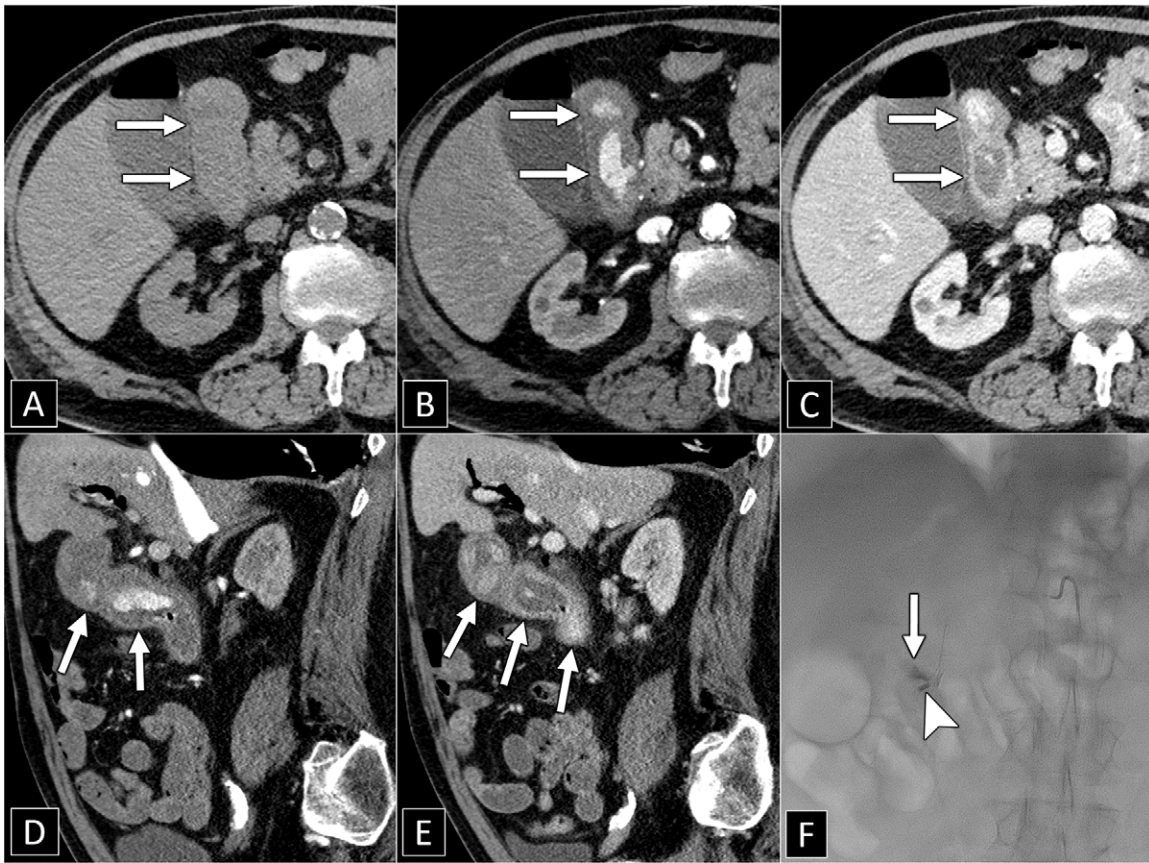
Actively bleeding duodenal ulcer in a 70-year-old man with a history of a large duodenal ulcer previously treated with endoscopic clipping who presented with recurrent gastrointestinal (GI) bleeding. (A) Noncontrast, (B) arterial phase axial and (D) sagittal, and (C) portal venous phase axial and (E) sagittal CT images show high-attenuation fluid in the duodenum on noncontrast images (arrows in A), representing a sentinel clot. On contrast-enhanced images, there is arterial phase contrast material extravasation in the duodenum (arrows in B and D), which changes in size and attenuation in the portal venous phase (arrows in C and E) consistent with contrast material extravasation. (F) Catheter angiography image shows a focus of contrast material extravasation (arrow) adjacent to a metal clip from a prior endoscopic procedure (arrowhead). The GI bleed was successfully treated with coil embolization.
